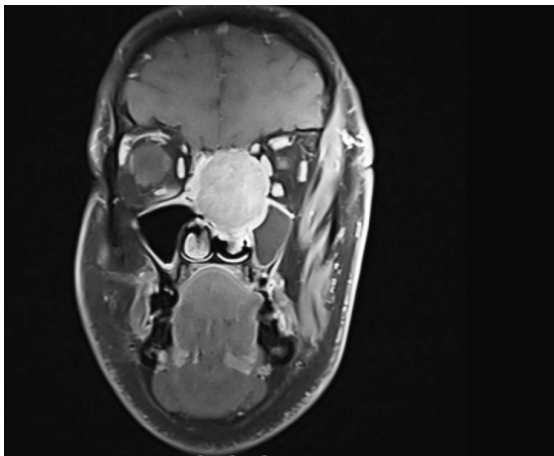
This paranasal T1-weighted MR imaging scan from the coronal view shows a contrasting lesion 41X33 mm in size in the left nasal cavity expanding towards the left maxillary sinus , inferomedial of the orbital and anterior skull base
